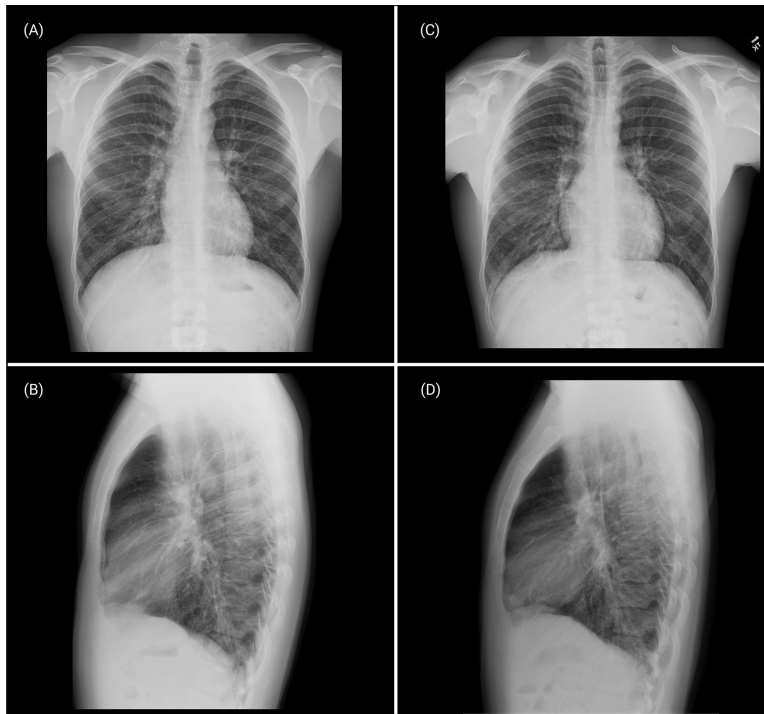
Posterior-anterior and standing lateral X-rays of Twin A (A, B) and Twin B (C, D) upon presentation to the Navy Special Warfare clinic endorsing SIPE symptomatology. Characteristic findings included right lower lobe and perihilar airspace consolidation with peripheral interlobular septal thickening. Radiograph formatting performed via licensed Biorender.
